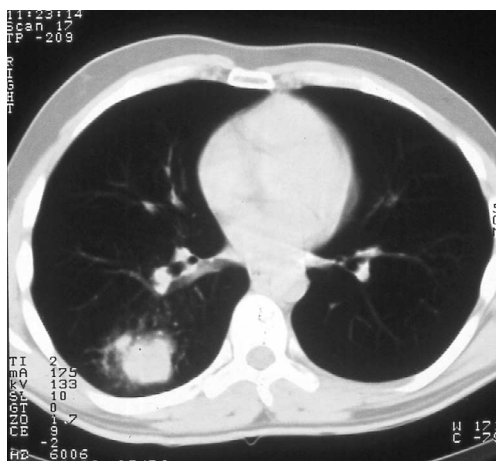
Computed tomography scan of thorax showing a pulmonary nodule in a patient with Wegener's granulomatosis. Biopsy showed a necrotizing vasculitis.
